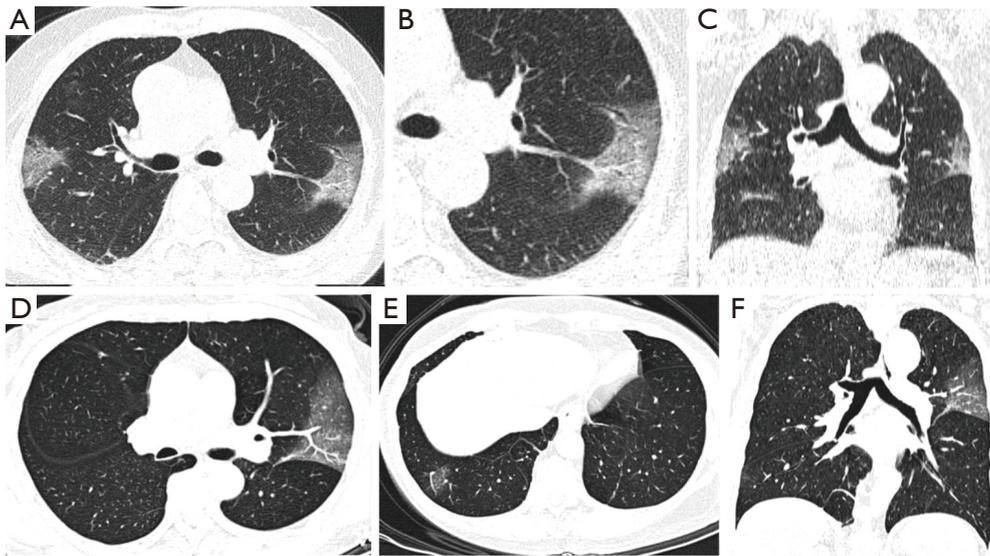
Chest CT findings of influenza A pneumonia in a 44-year-old male (H1N1 infection). (A,B,C,D) Multifocal GGO, partial consolidation and consolidation in both lungs (arrow in A, D shows consolidation in right middle lobe); (B) tree-in-bud (white arrow). (C) Coronal view. CT, computed tomography; GGO, ground-glass opacity.
